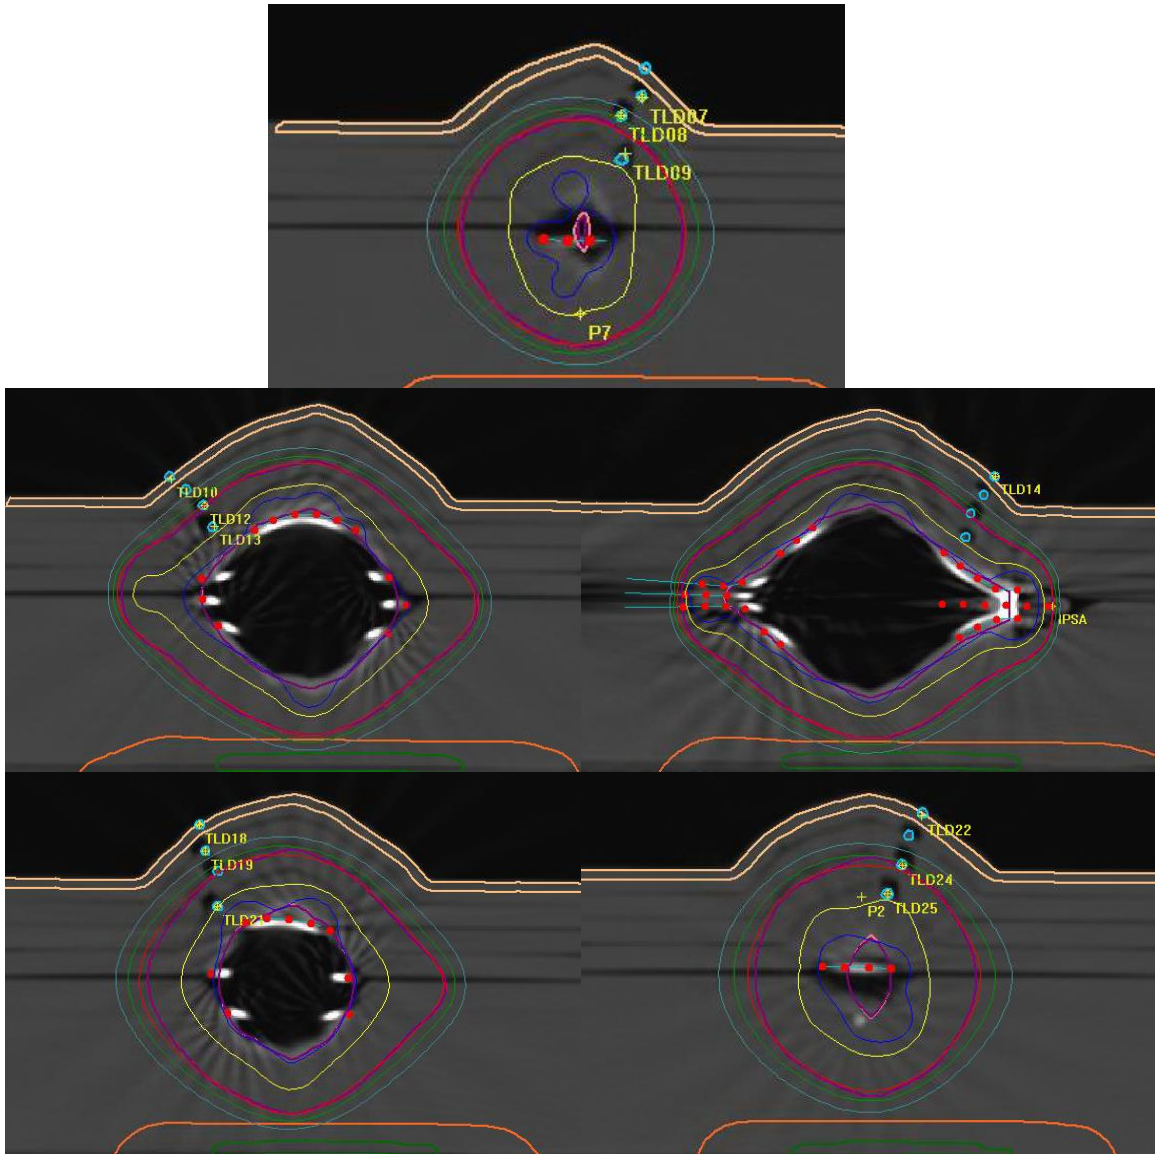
CT images of the 3D prints and the reconstructed structures on test 2.*
